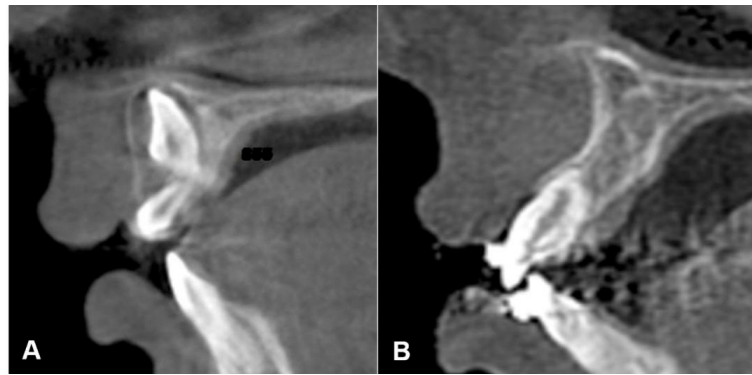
Tomographic images A. Initial sagittal section of tooth 11 evaluated in CBCT. B. Final sagittal section of tooth 11 evaluated in CBCT.
